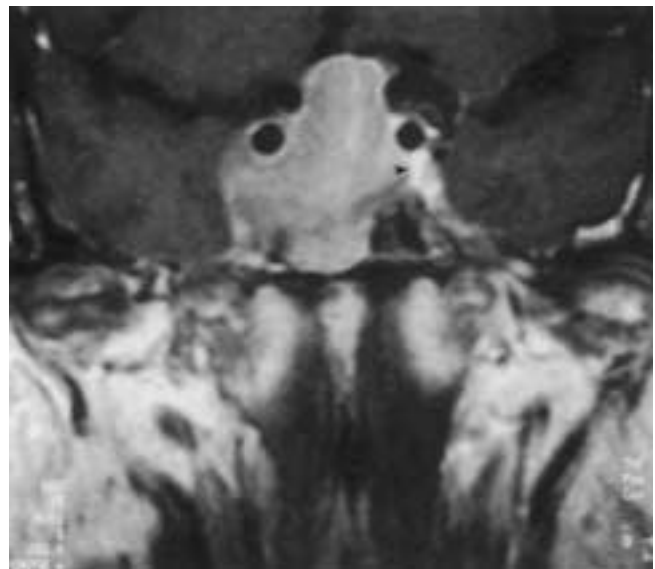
Invasive pituitary adenoma. Coronal postcontrast T1-weighted MR image. The adenoma shows intermediate enhancement, but the margin (*arrowhead*) between the adenoma and the normal cavernous sinus can be easily appreciated on the left-hand side. On the right side the adenoma extends further into the cavernous sinus, wrapping partially around the carotid artery. There is also inferior extension into the sphenoid body.
